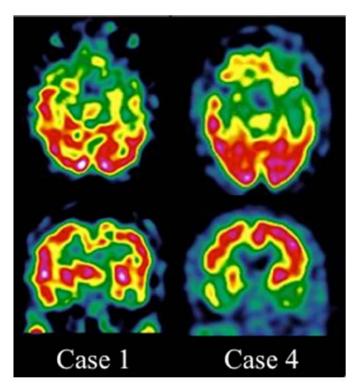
Brain SPECT images of cases 1 and 4, showing marked bitemporal hypoperfusion
